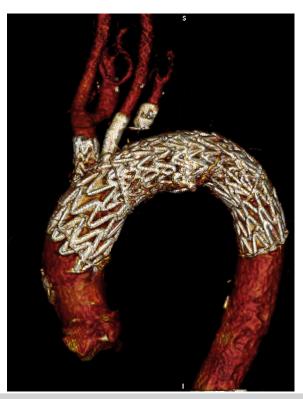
Postoperative computed tomography (CT) rendering of thoracic endovascular aortic repair (TEVAR) and double chimney grafts of aortic arch: iliac branch Excluder for anonymous trunk and Viabahn for left common carotid artery.
